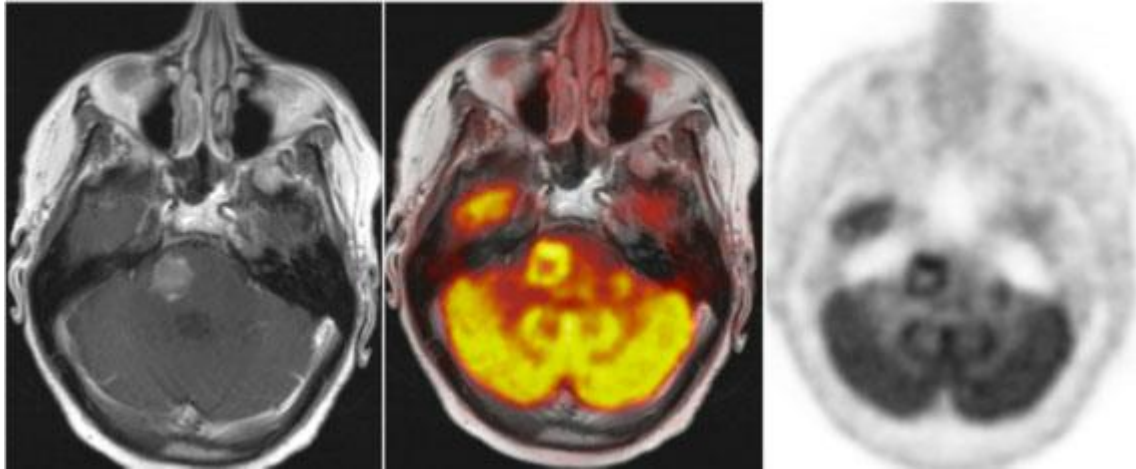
Simultaneous PET/MRI in a patient with intracranial metastatic disease. Post-contrast T1 weighted MRI (left image) demonstrates an enhancing lesion near the skull base which may represent either radiation changes or residual tumor. FDG PET imaging (right image) demonstrates increased avidity within the lesion helping characterize the lesion as being tumor rather than treatment related effect.
